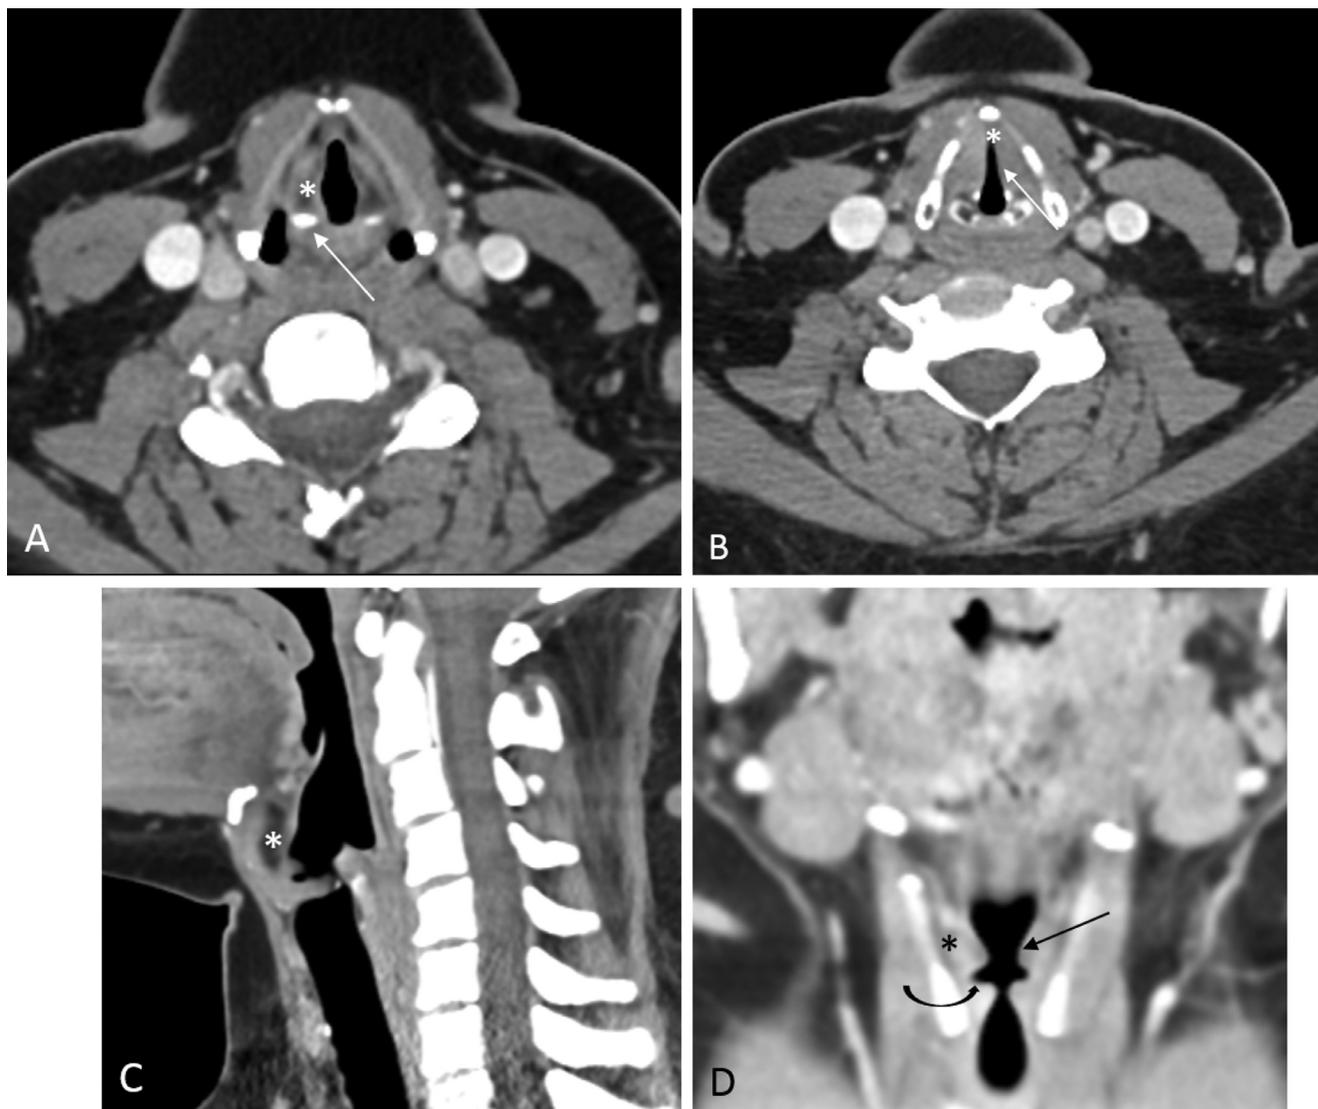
CT imaging of the larynx. (A) Axial contrast-enhanced CT scan at the level of the supraglottis. The right arytenoid cartilage (arrow) is demonstrated posterior to the false vocal cord, which creates the roof of the laryngeal ventricle. The right paraglottic space (asterisk) is demonstrated lateral to the false vocal cord. (B) Axial contrast-enhanced CT scan at the level of the glottis. The cricoarytenoid joints are visible, with the posterior commissure in between. The thyroarytenoid muscle (arrow) forms the bulk of the vocal cord. The asterisk marks the anterior commissure. (C) Sagittal contrast-enhanced CT scan of the larynx. The epiglottis is visible with the fat containing pre-epiglottic space anterior to it (asterisk). (D) Coronal contrast-enhanced CT image of the larynx demonstrates the false cords (arrow points to left false cord), laryngeal ventricles (curved arrow points to right ventricle), and paraglottic spaces (asterisk points to right paraglottic space).
